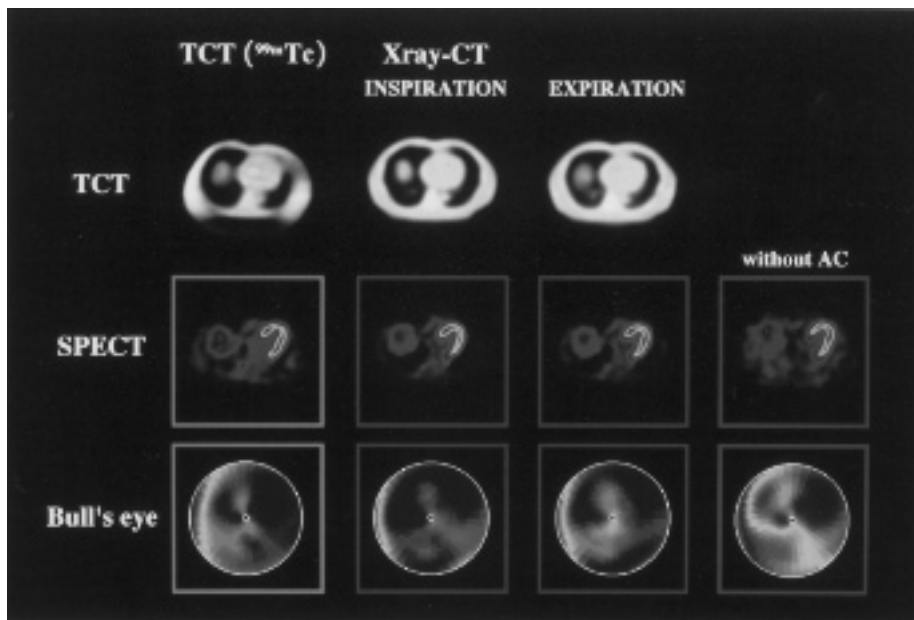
Difference of the scanning protocol of the X-ray CT of a healthy subject, TCT map, SPECT image, and Bull's eye map are shown.
